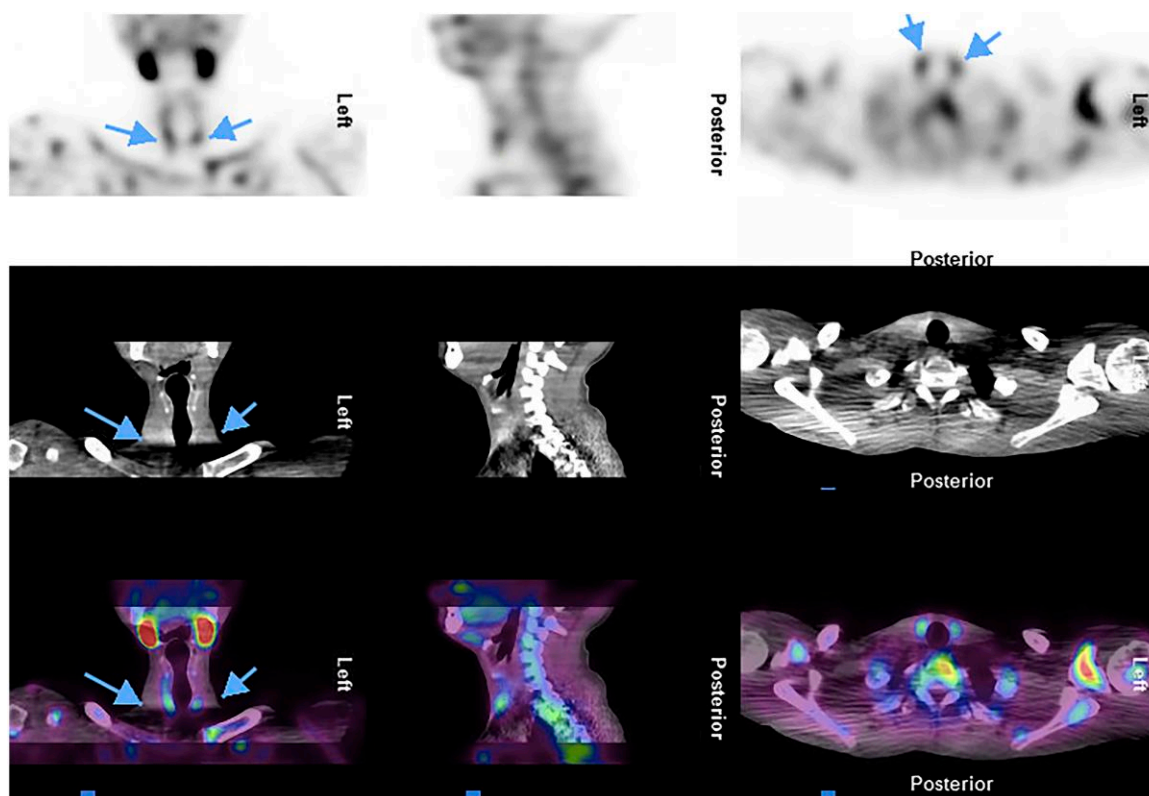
The nuclear medicine parathyroid scan using single photon emission tomography/computed tomography indicated a slight elevation in uptake, suggesting potential abnormal parathyroid tissue in the lower poles of both sides, as indicated by arrows. This heightened uptake became more evident 60 minutes after the administration of the radioisotope.
